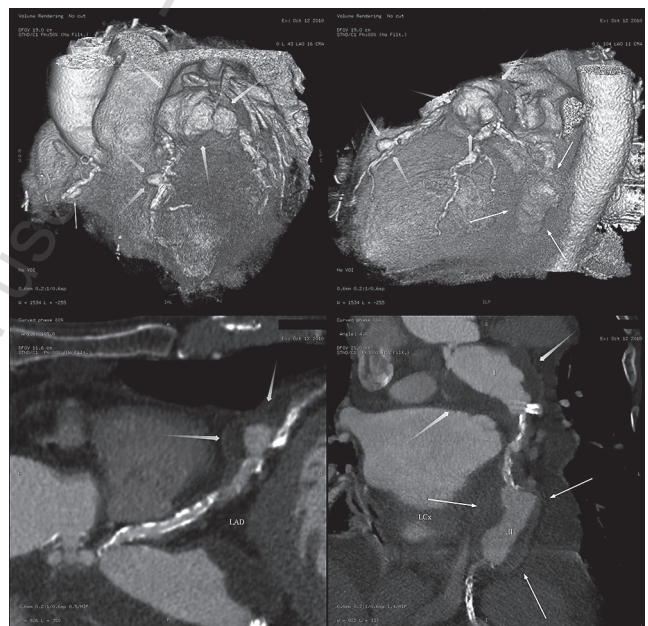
Multislice CT scan of the heart. Volume rendering (VR) images and curved multiplanar reformatted images demonstrates: the aneurysm of mid LAD (blue arrows), the aneurysm of the proximal LCx (green arrows) and the aneurysm of mid LCx (white arrows); white spots reflect calcified atherosclerotic plaques.
